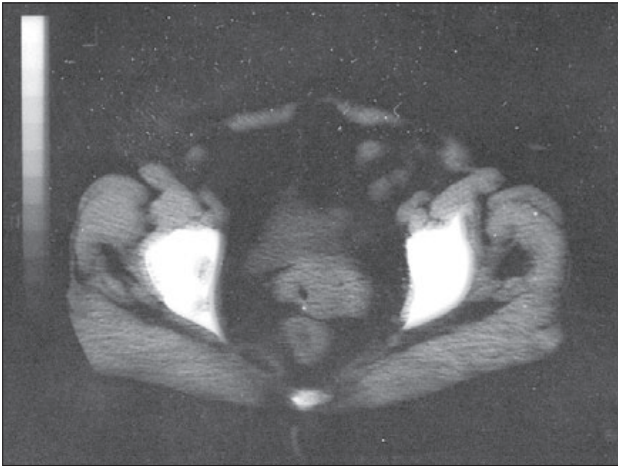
a, b. Abdominal CT revealed an enlargement of vaginal cuff and anterior vaginal wall.
